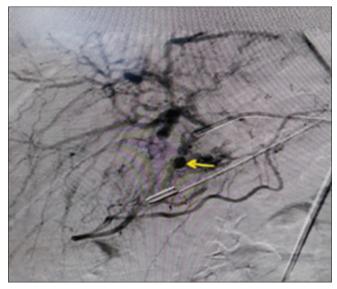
Computed tomography angiography showing pseudoaneurysm from the gastroduodenal artery.
